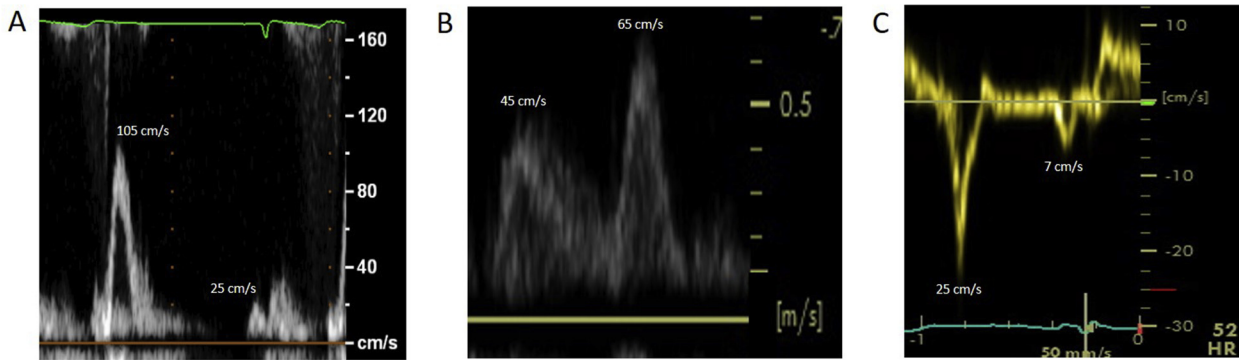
Transthoracic echocardiographic imaging demonstrating complementary indices of supra-normal left ventricular diastolic function in a healthy endurance-sport athlete. (A) Trans-mitral pulsed-wave Doppler imaging showing E-wave prominence with an E/A ratio >2.0 . (B) Pulmonary vein pulsed-wave Doppler showing D-wave predominance due to rapid relaxation and brisk early diastolic left ventricular filling. (C) Tissue Doppler of the lateral mitral annulus showing e' prominence with early diastolic relaxation velocities in excess of 20 cm/s.
